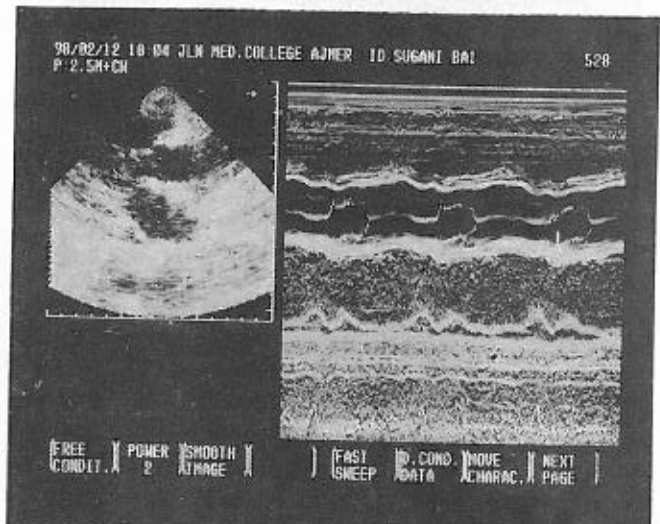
Parasternal long axis view showing mild pericardial effusion and distinct left atrial posterior wall motion.
